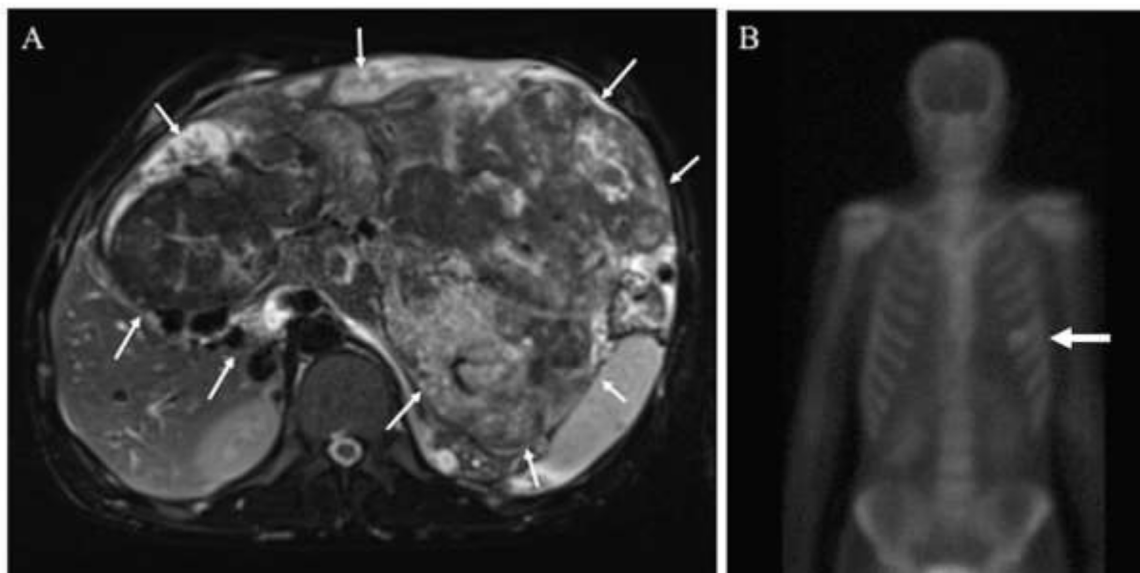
(A) Gadoxetic acid-enhanced MRI axial T2-weighted showed large inhomogeneous abdominal mass and continuation with the parenchyma of left hepatic lobe (arrows). (B) Single-photon emission computed tomography (SPECT) showed metastasis of fifth left rib (arrow).
